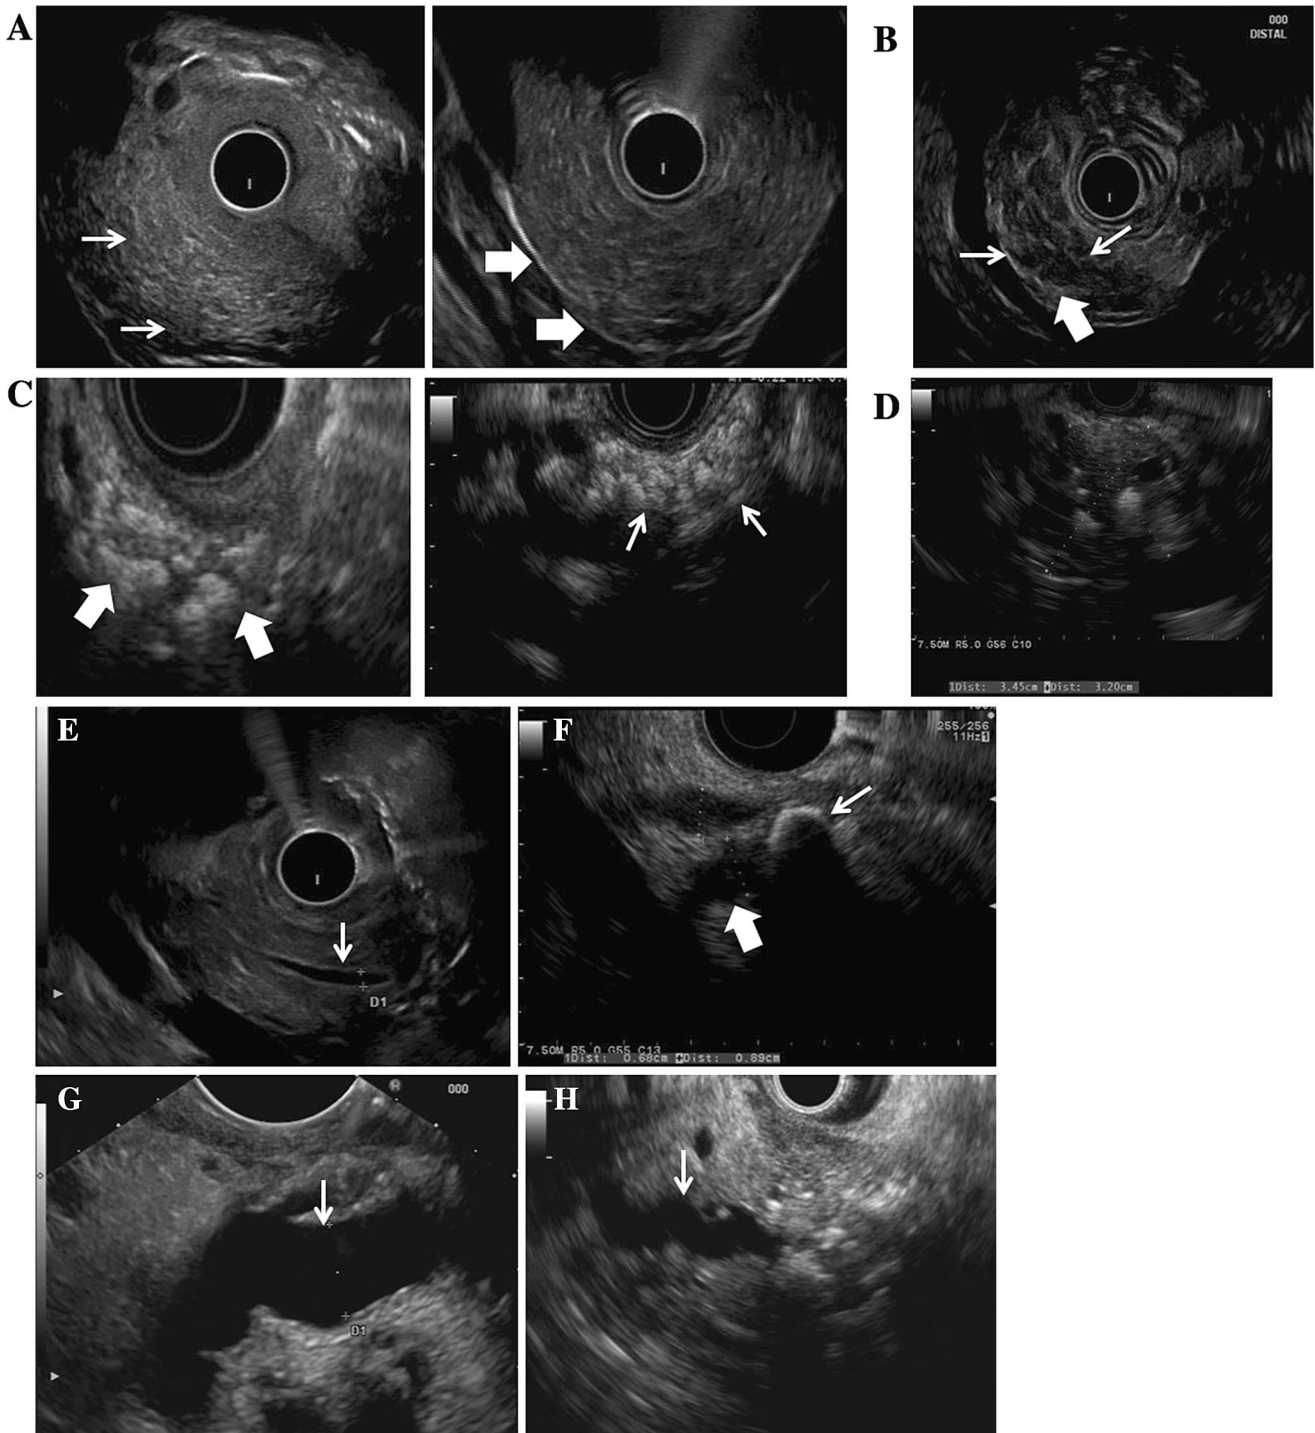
Endoscopic ultrasound (EUS): Parenchymal features in chronic pancreatitis. A normal head (*thin arrows*) and body (*thick arrows*); B honeycomb lobularity (*thin arrows*), Major B criteria, and stranding (*thick arrow*), Minor criteria; C parenchymal shadowing calcifications in the head (*thick arrows*) and body (*thin arrows*), Major A criteria; D pseudo-mass (with measuring
